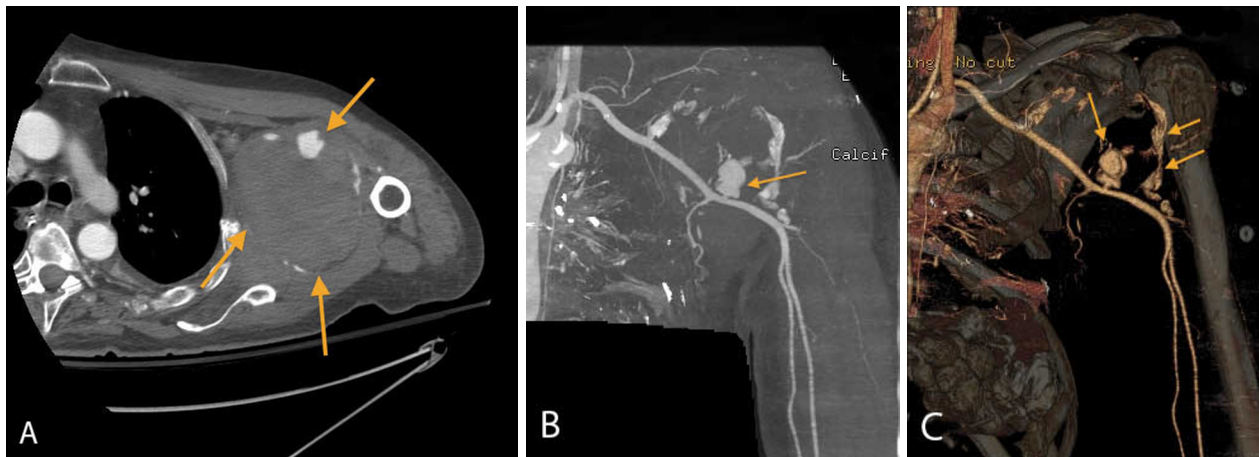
A. Left-upper-extremity CT-angiography with contrast, axial view. The PSA as seen on initial diagnostic imaging, demonstrating a narrow neck with approximately 10 cm total diameter. The active PSA lumen (upper arrow) can be seen as a relatively small portion of the overall hematoma formation (lower arrows). B. Left-upper-extremity CT-angiography with contrast, coronal view. Initial diagnostic imaging, showing a coronal view of the PSA lumen. C. Left-upper-extremity CT-angiography, 3D with color. This digitally recreated 3D image demonstrates the active PSA lumen (left arrow) and the distal edge of the hematoma formation, as evidenced by a small amount of contrast enhancement (right arrows).
